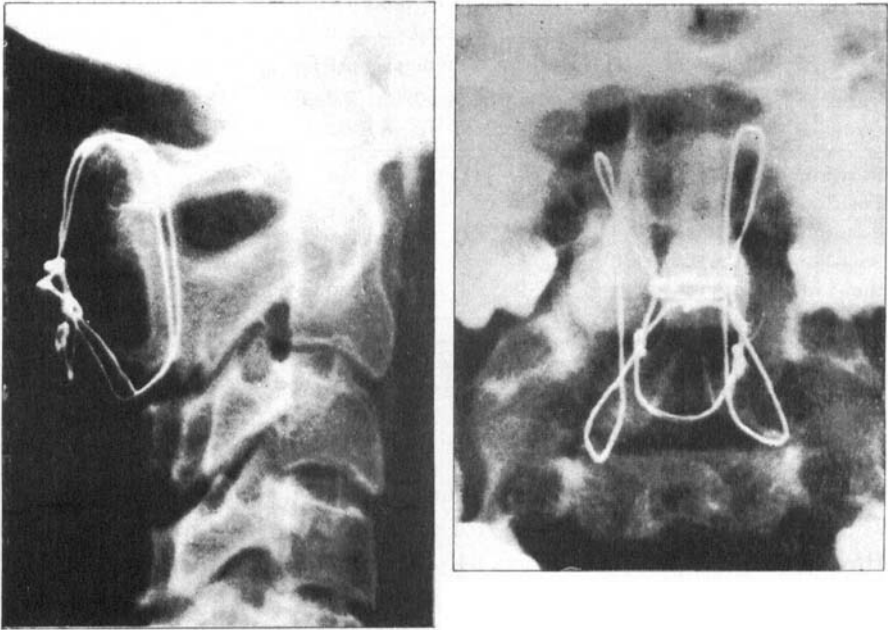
A 17-year-old girl with a fracture of the odontoid process of the axis. X-ray film of fusion viewed from the lateral (a) and anterior (b) aspect. Solid union of the graft 3 years after the operation. Note the steel wire arrangement and the graft which projects between the arches of C1 and C2.
